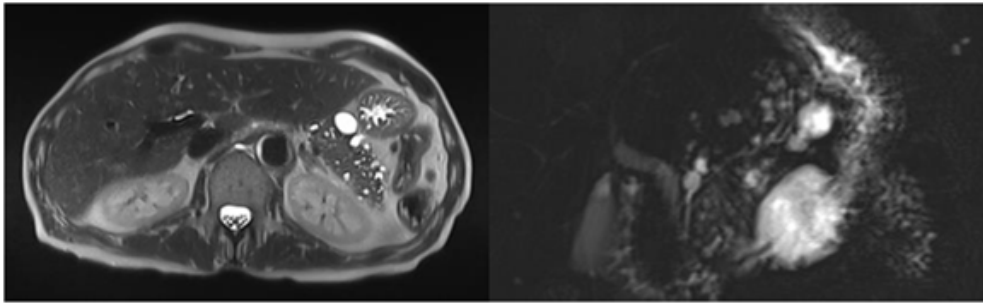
MRI findings of case 1
